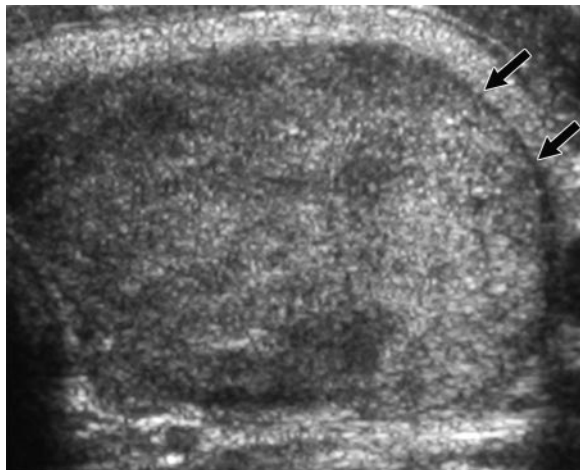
Follicular adenoma in a 30-year-old woman. Transverse sonogram of the left lobe of the thyroid shows a follicular adenoma with a hypochoic halo (arrows).
